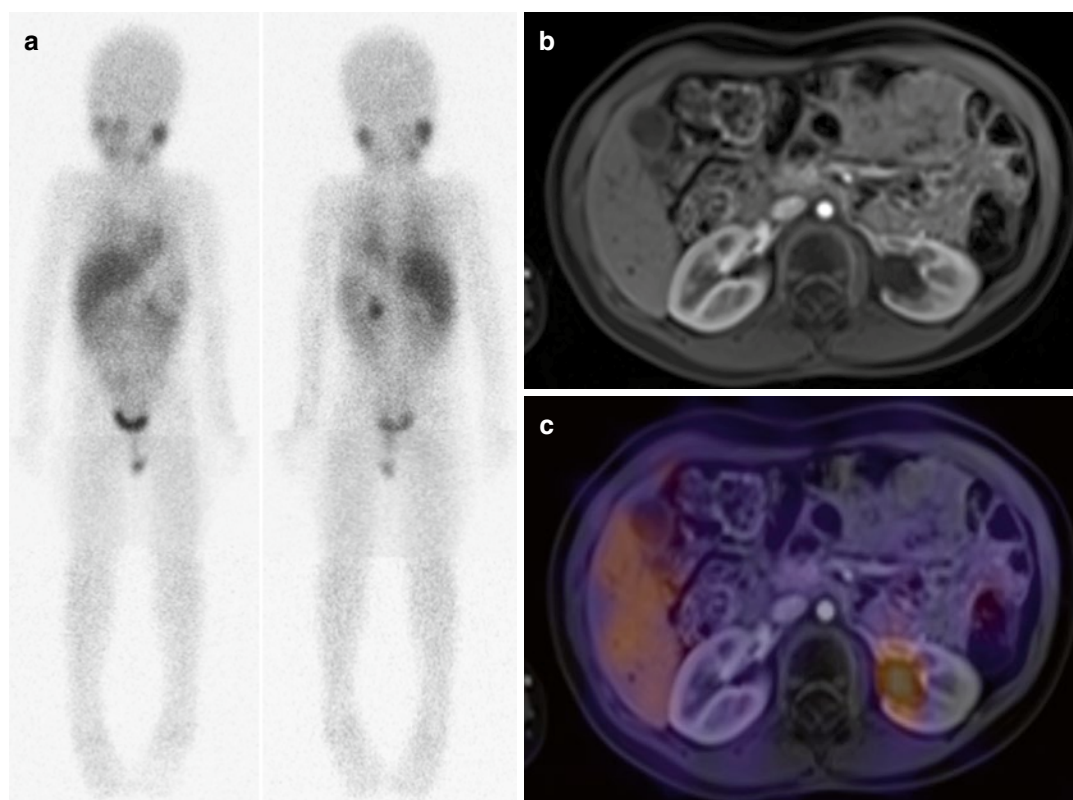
Iodine-123-MIBG SPECT and CT co-registration are useful to exclude recurrent tumor. (a) After resection of a large left suprarenal neuroblastoma, a postoperative restaging ^{123}I -MIBG whole-body scan in anterior and posterior projections shows intense tracer accumulation in the left upper quadrant and a small focus of mild uptake in the right upper quadrant. (b) A contrast-enhanced CT of the abdomen shows a dilated left renal
